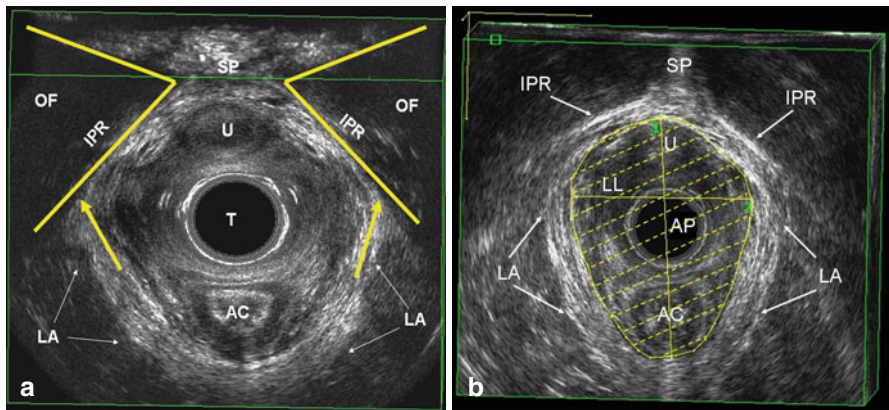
3D endovaginal ultrasound. (a) Levator ani (LA) is visualized as a multilayer hyper-echoic sling coursing lateral to the vagina and posteriorly to the anal canal (AC) and attaching to the inferior pubic rami (IPR) anteriorly. (b) The biometric indices of the levator hiatus are measured in the axial plane of minimal hiatal dimensions. AP Anterior-posterior diameter, LL latero-lateral diameter, OF obturator foramen, SP symphysis pubis, T transducer, U urethra
